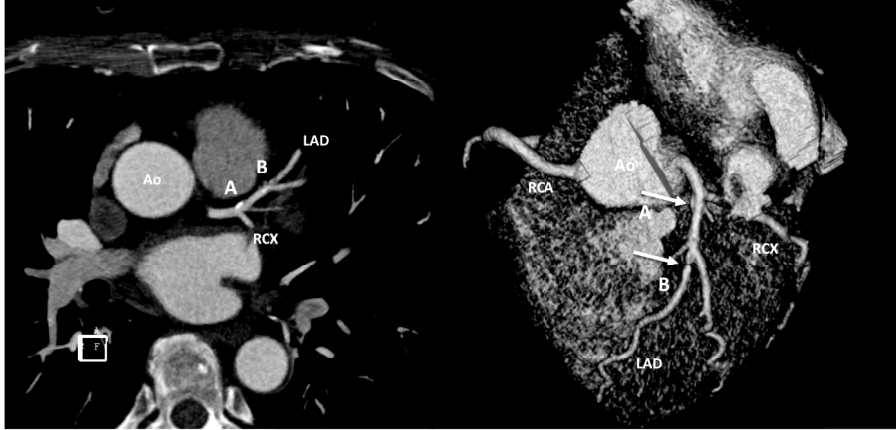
Example of cardiac CT imaging (left: raw data; right: volume rendered image).
